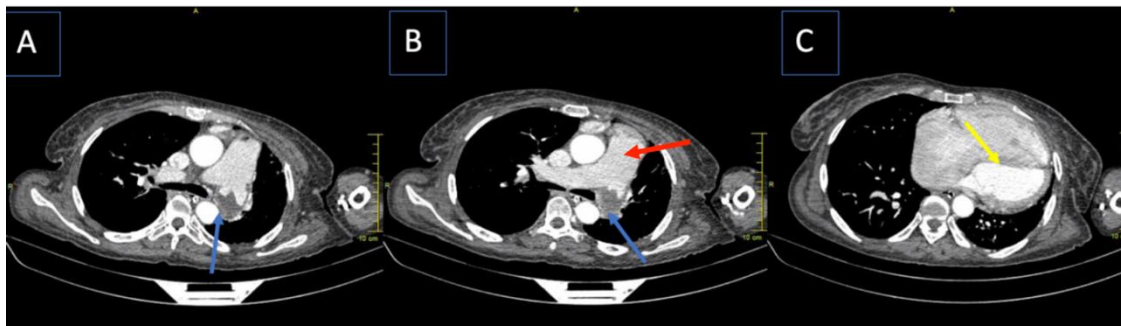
A, B and C: Axial sections of CT with contrast injection showing occlusive thrombus of the left branch of the pulmonary artery (A, B) (blue arrow), dilation of the TAP (red arrow) and significant right atrioventricular dilation (C) with a dysmorphic septum, curved towards the left ventricle (yellow arrow) in a 52-year-old patient received for suspected intermediate probability PE according to the Wells score and the revised Geneva score.
